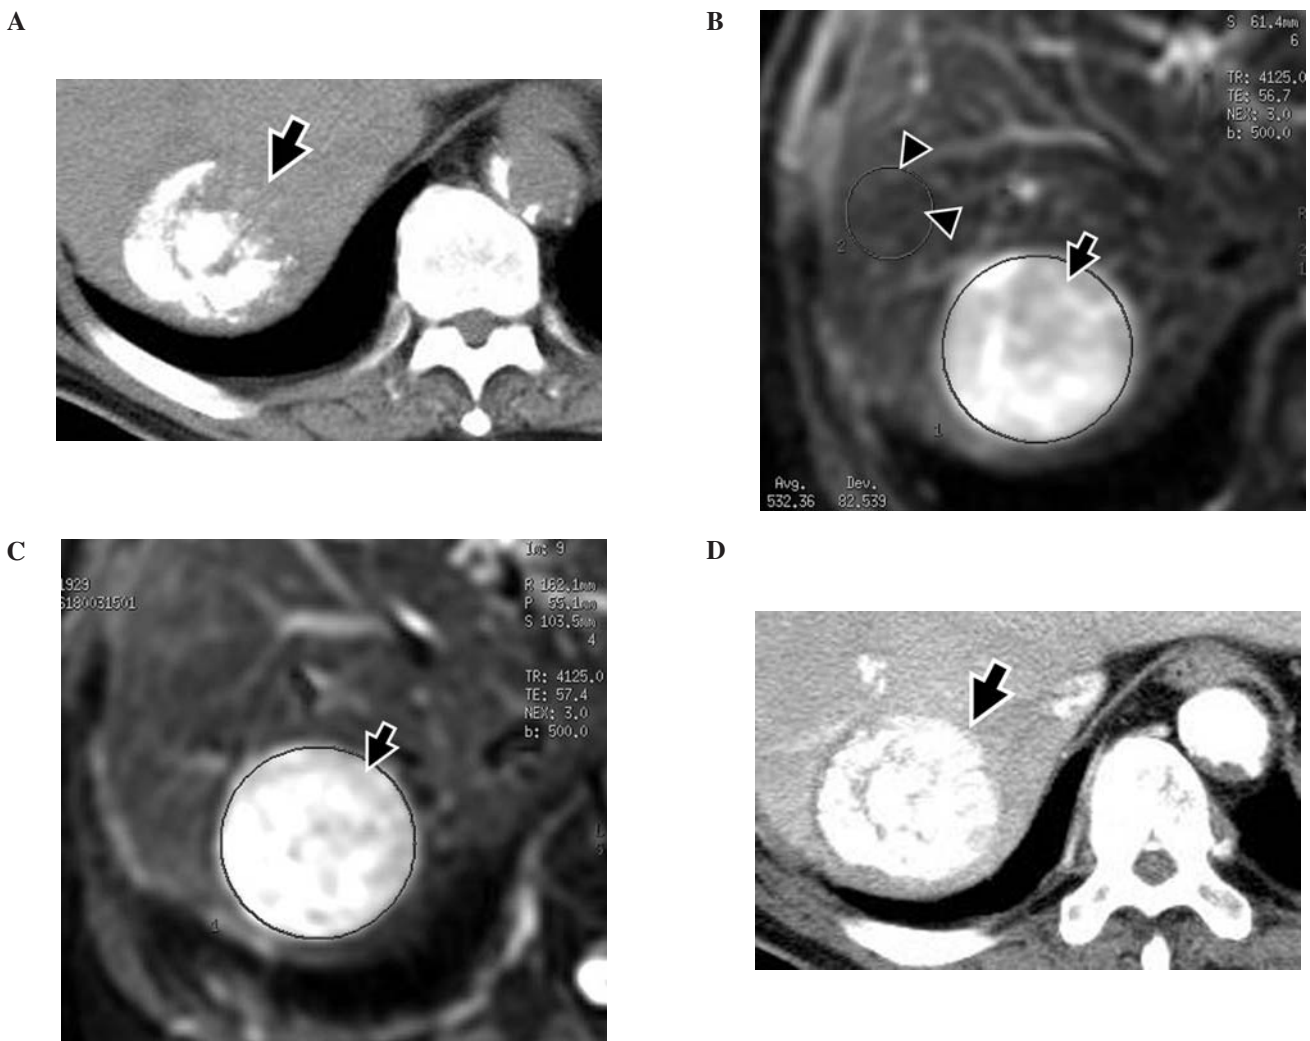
A 69-year-old man with a 4.8-cm HCC in the right hepatic lobe. (A) Iodized-oil CT shows incomplete retention of iodized oil in the tumor (arrow). (B, C) DWI before (B) and after (C) TACE displayed on the Functool workstation monitor. Regions of interest were placed in the tumor (arrow) and surrounding hepatic parenchyma (arrowhead). DWI shows hyperintense signals in tumor both before and after TACE (arrow). ADC in the tumor after TACE ($1.02 \times 10^{-3} \text{ mm}^2/\text{s}$) was not elevated compared to that before TACE ($1.1 \times 10^{-3} \text{ mm}^2/\text{s}$) (%ADC, -7.3%). Mean ADC in surrounding hepatic parenchyma ($1.21 \times 10^{-3} \text{ mm}^2/\text{s}$) resembled that of HCC before TACE ($1.1 \times 10^{-3} \text{ mm}^2/\text{s}$). (D) Contrast-enhanced CT at 3 months after TACE revealed tumor relapse close to iodized oil retention (arrow).
